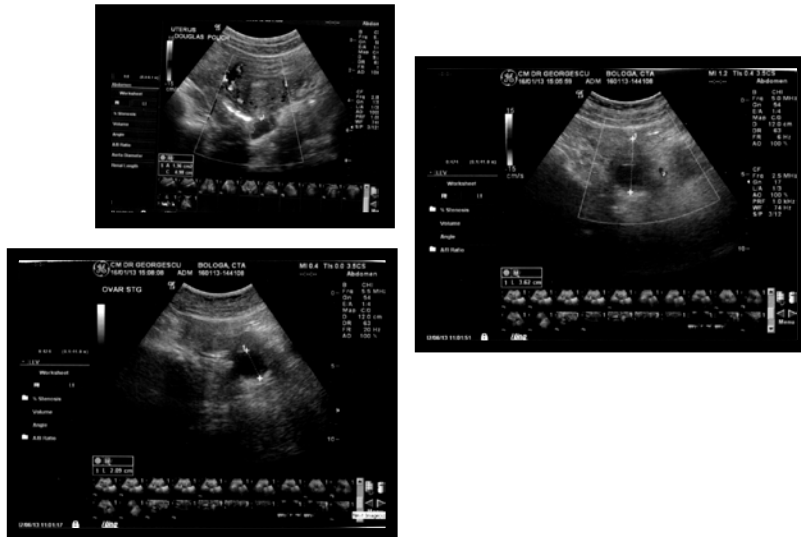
Ultrasound features of ovary cyst and ascites
